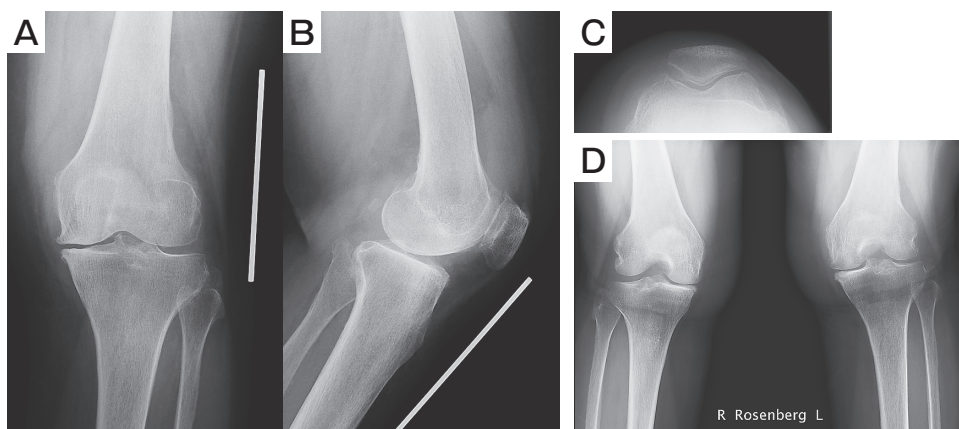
Case 2. Radiograph before operation. A, AP; B, lateral; C, skyline; D, Rosenberg view.
